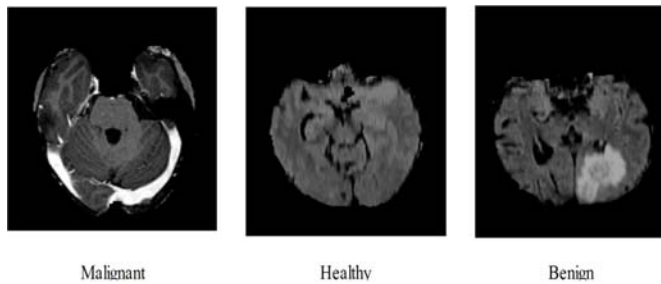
Sample brain tumor MRI images.
